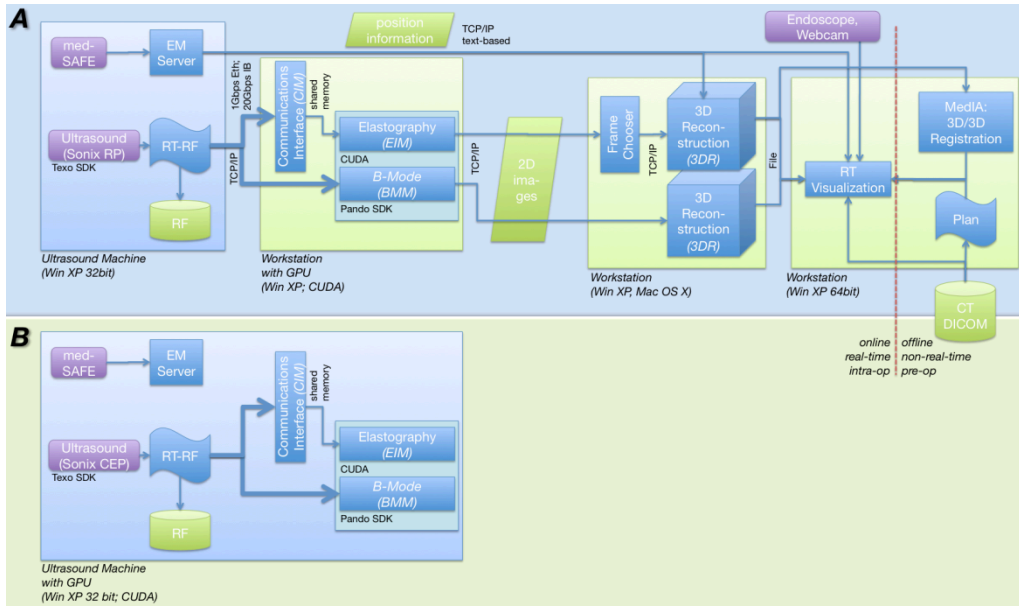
Proposed system software architecture, implemented in two different system setups. In the more comprehensive Setup A, 2D ultrasound data (left) is combined with position data into a 3D reconstruction (center), which can then be registered with CT (right) and visualized. Setup B represents a separate, standalone 2D B-Mode/EI workstation.
